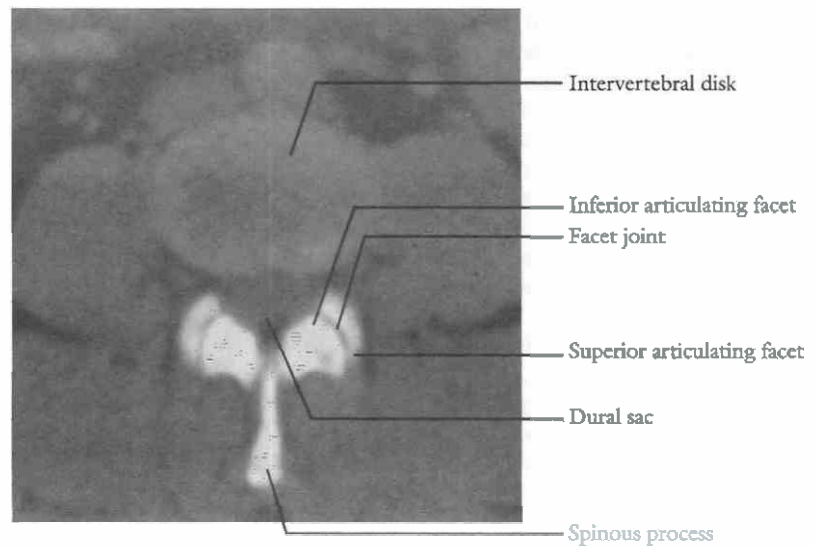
Axial CT scan through the intervertebral disk in the midlumbar region. Minimal averaging of the cortex causes increased attenuation value at the periphery. At these regular window and level settings, the facet joints cannot be readily seen. The fat in the epidural space is seen within the intervertebral foramen and posterior to the thecal sac.
